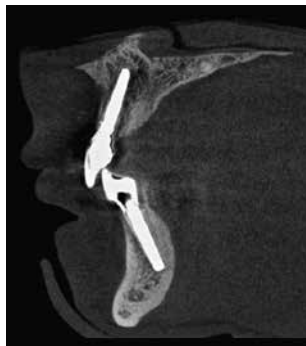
One-year CBCT evaluation of the fully guided implant placement.
